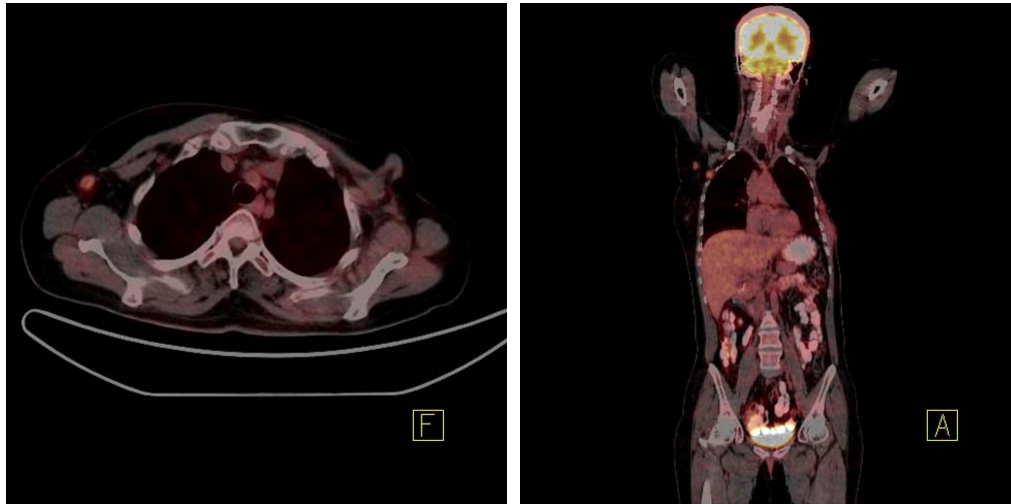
PET-CT imaging revealed right axillary (22 mm, SUV max 4,8) lymphadenopathy.
